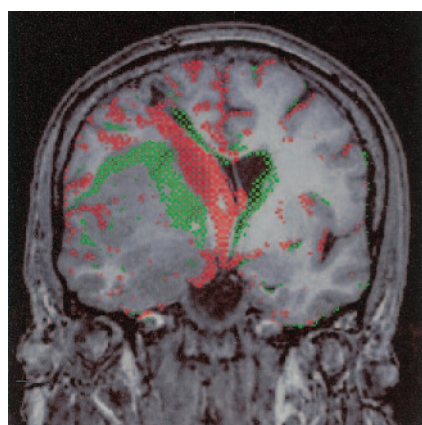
Difference image of volumetric pre- and post-treatment studies. Red-green difference image of pre- and post-treatment coregistered nonenhanced T1-weighted volumetric images (14.4/ 6.4/1[TR/TE/NEX]) with a section thickness of 1 mm. Green indicates a shift from lower to higher signal intensity between the first and second study; red, the reverse. Reduction in size of the superior (mostly insular) tumor component is shown in green, which indicates replacement of T1-hypointense tumor by tissue of higher signal intensity. Re-expansion of the hypointense CSF spaces because of a decrease in mass effect is indicated in red (this includes a track leading down to the right lateral ventricle, which is related to a previous biopsy). Note the absence of boundary shifts of the temporal tumor component between the pre- and post-treatment studies.
